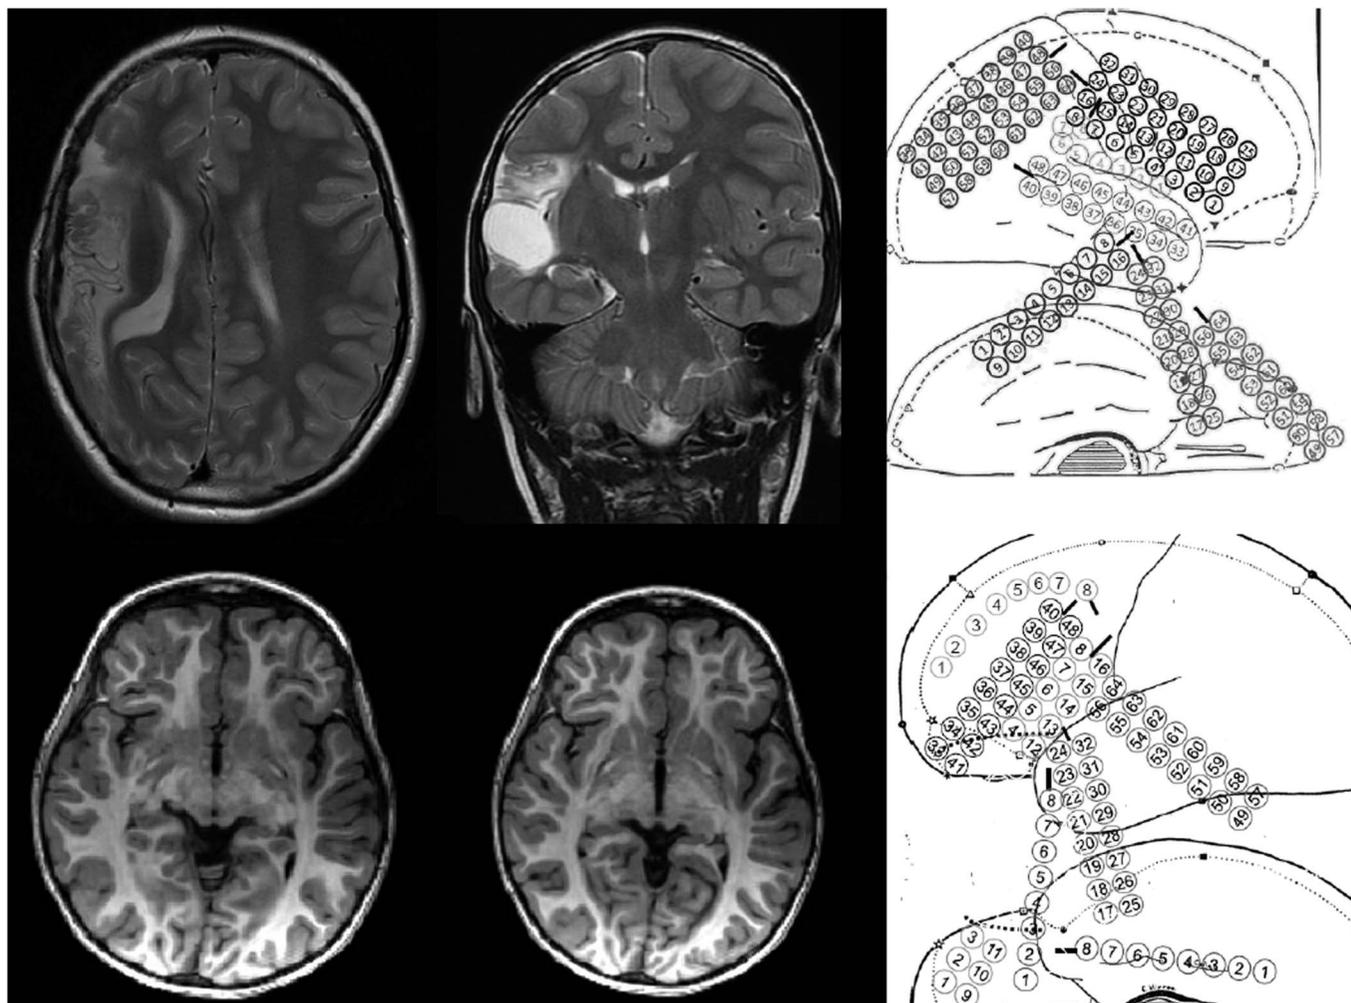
Examples of lesions and grid coverage in our patient population. Patient 2 had a stroke in the distribution of the left middle cerebral artery (upper row, axial view T2-weighted image and coronal view T2-weighted image), and grids and strips covered a wide area around it (upper row, electrode scheme). Patient 9 had a cortical dysplasia affecting the left frontal lobe (lower row, axial views in T1-weighted images), and grids and strips covered a wide area around it (lower row, electrode distribution scheme).
